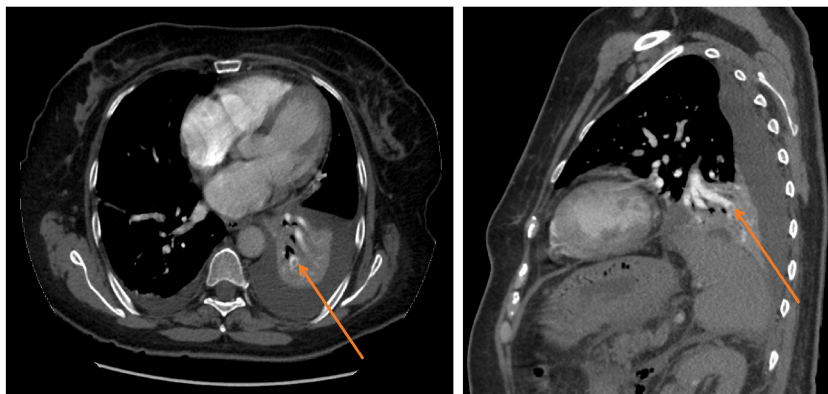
CT Chest from day 4 of admission showing a filling defect at the posterior segmental branch of the left lower lobar artery, suggestive of acute pulmonary embolism. Also a mild bilateral pleural effusion with complete collapse of the left lower lobe.
